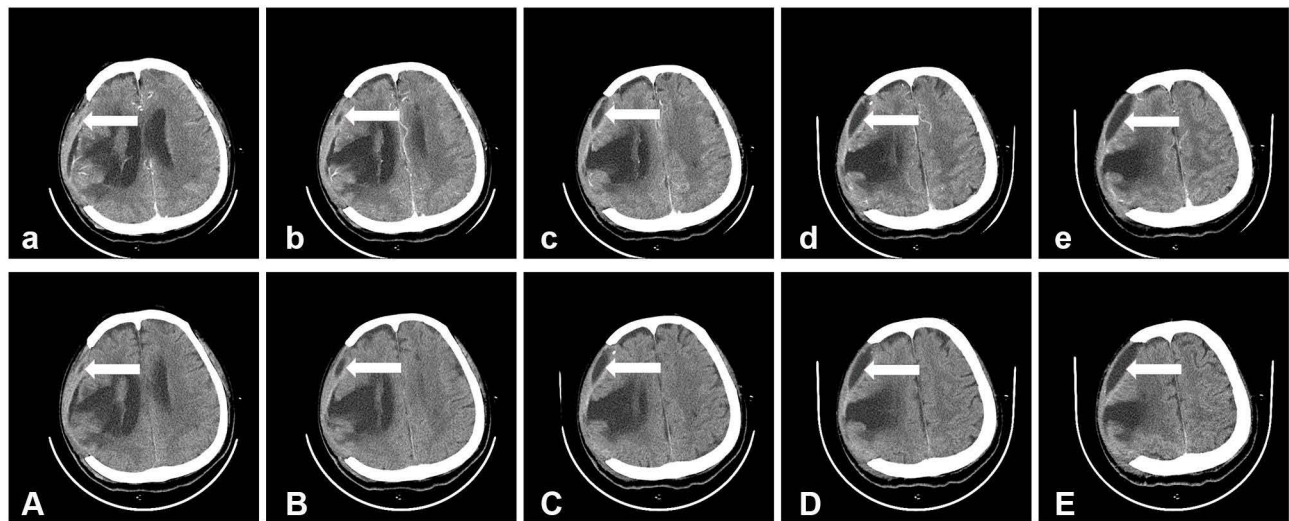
Brain CT plain scan results. Postoperative reexamination of intracerebral hemorrhage in the thalamus and Corona radiata areas in the right basal ganglia region revealed meningoencephalitis in the right cerebral hemisphere, and a small amount of subdural/extradural effusion in the operative area (arrow). Multiple softening foci in the brain, roughly the same as before (a–e). A contrast-enhanced brain CT on August 18 revealed a small amount of fluid within the subdural space adjacent to the right frontal lobe. An enhanced scan showed mild to moderate enhancement. There was a strip-like low-density shadow in the operative area of the right brain and a softening lesion in the right vertebral temporal lobe, which was partially connected with the adjacent ventricle. Small patches of low-density shadow were observed in bilateral basal ganglia, right midbrain, and left Corona radiata, and some edges were blurred.(A–E) No obvious abnormal enhanced shadow was observed on the enhanced scan.
